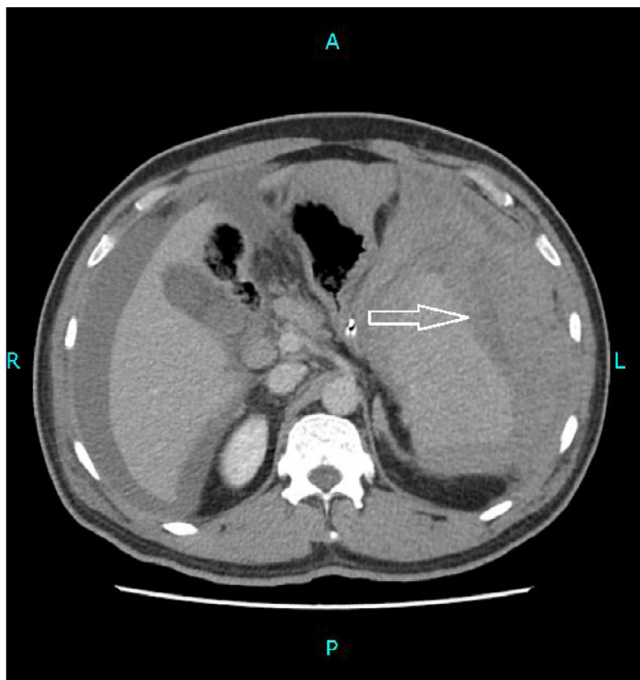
CT scan abdomen and pelvis with contrast (coronal view) showing hematoma in the perisplenic and sub diaphragmatic region as shown by the arrow.
